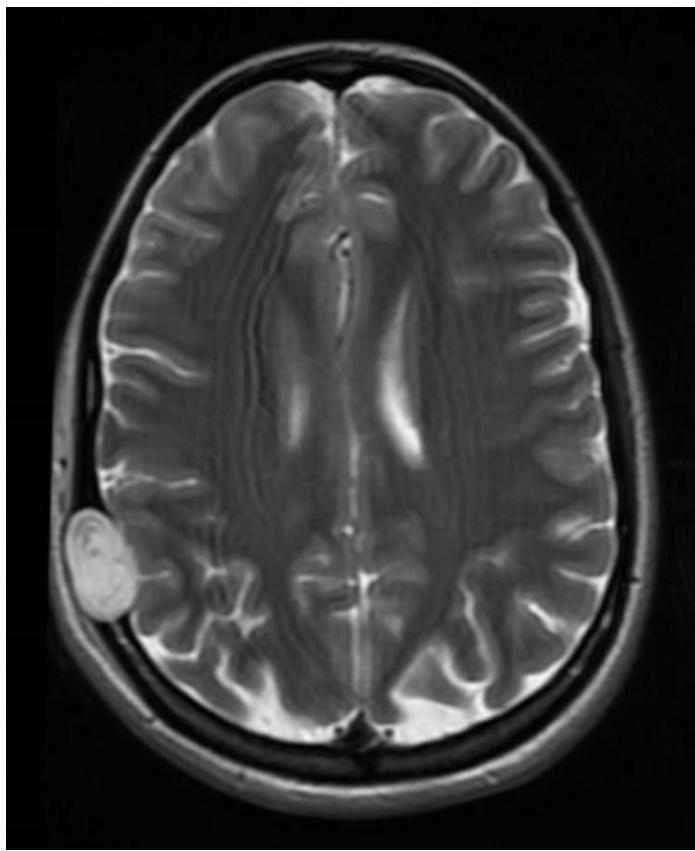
T2-weighted magnetic resonance image showing a 2.5cm lesion of the right parietal calvarium.
